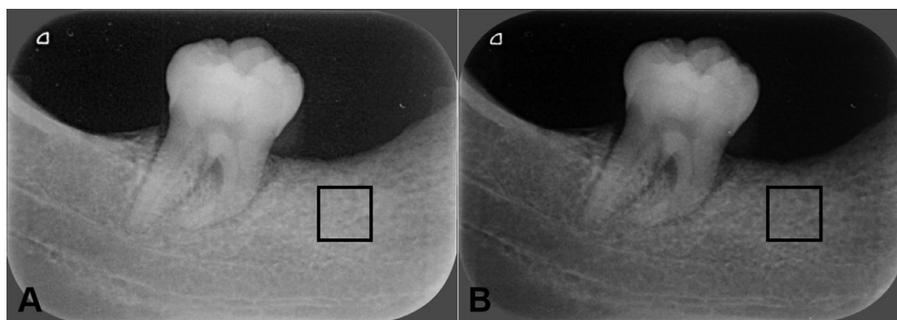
Radiographic images at different spatial resolutions with the region of interest (black-outlined square) positioned on the same anatomic region. A, 1270 dpi. B, 2000 dpi.
